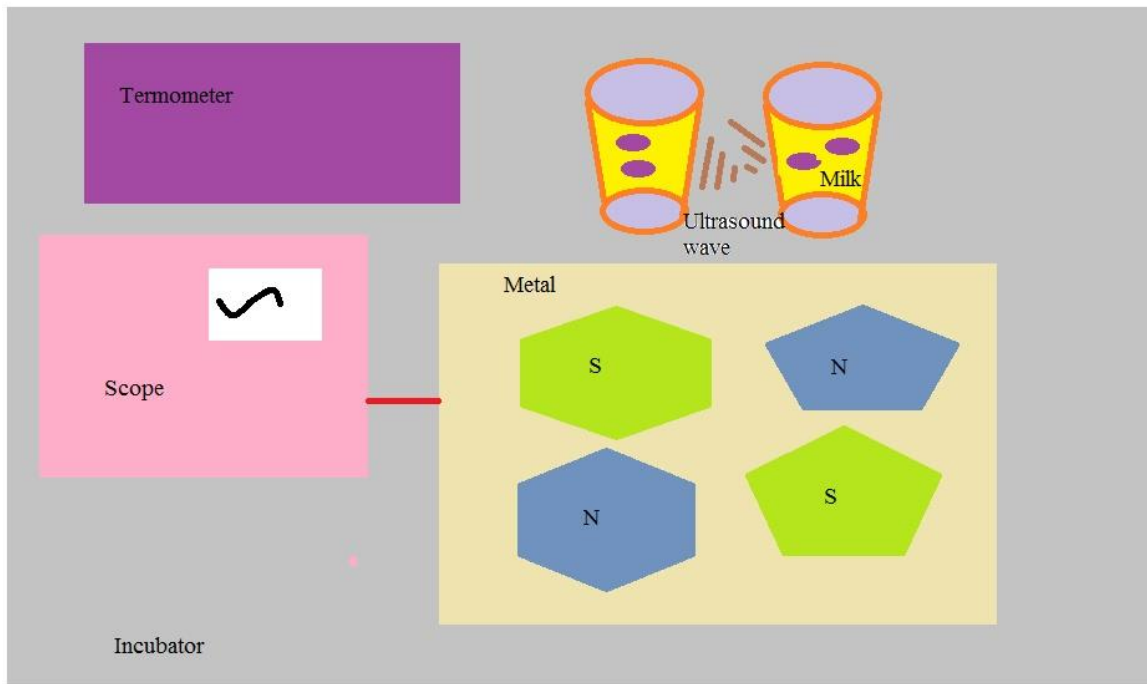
A circuit for taking DNA ultrasound waves
